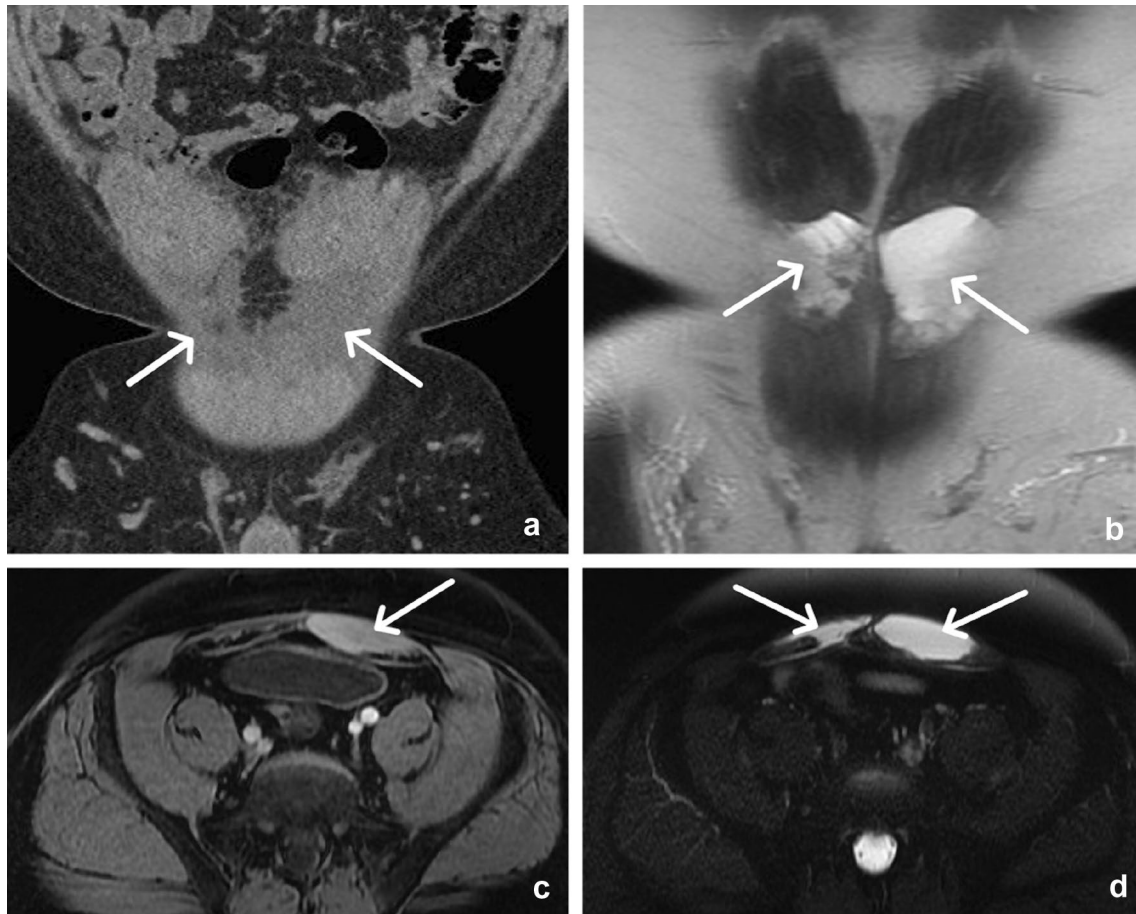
20-year-old man with rectus abdominis muscle strain from abdominal crunches. Coronal CT (a) demonstrates bilateral low attenuation involving the rectus abdominis muscles (arrows). Coronal T2W (b), axial T1W (c), and axial T2W fat-saturated (d) MR images
